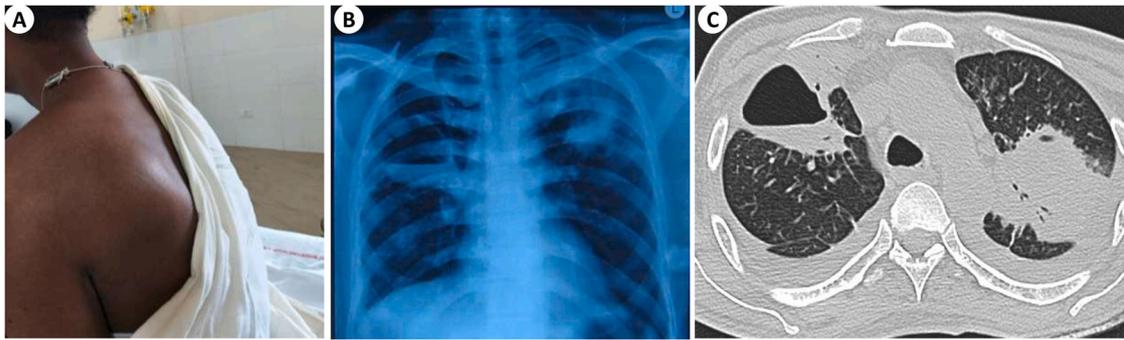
Post-COVID vaccination abscess manifesting as (A) soft-tissue inflammation and swelling on the back, below the left shoulder, (B) bilateral lung abscess on chest radiograph and (C) bilateral lung abscess with pleural effusion on computed –tomography scan.
